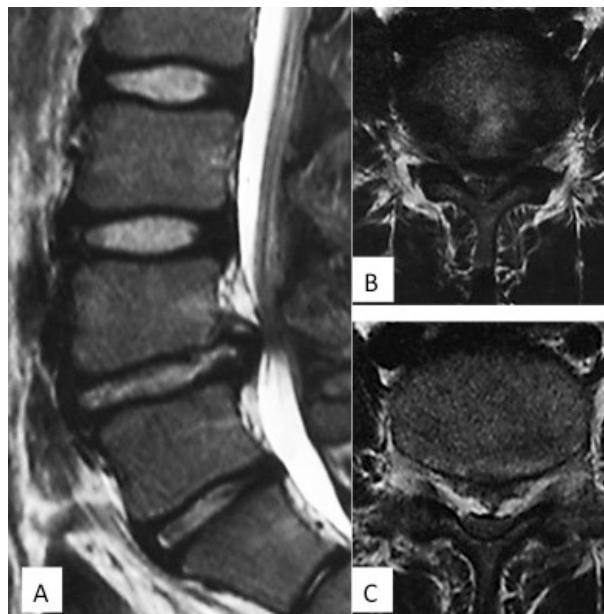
Sagittal (A) and axial T1 (B) and T2 (C)-weighted magnetic resonance image showing degenerative change and protrusion of the L4/5 disc, but no corresponding bony fragment was clearly seen
